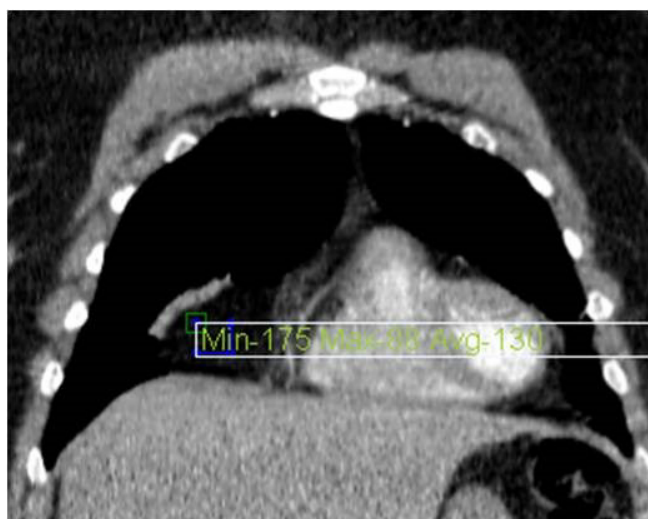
Coronal enhanced thorax CT revealed that atelectasis due to increased right cardiophrenic fatty tissue (- 130 HU).
